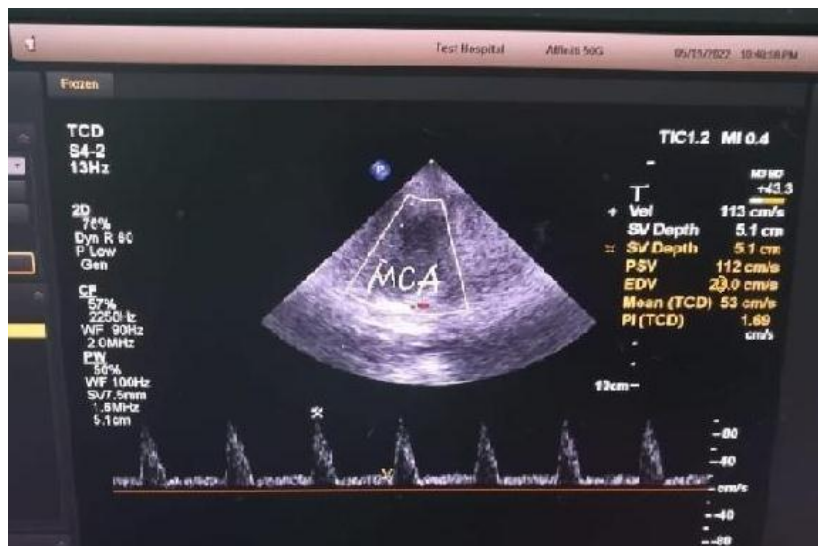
Transcranial Doppler of RT MCA suggesting cerebral hypoperfusion.
